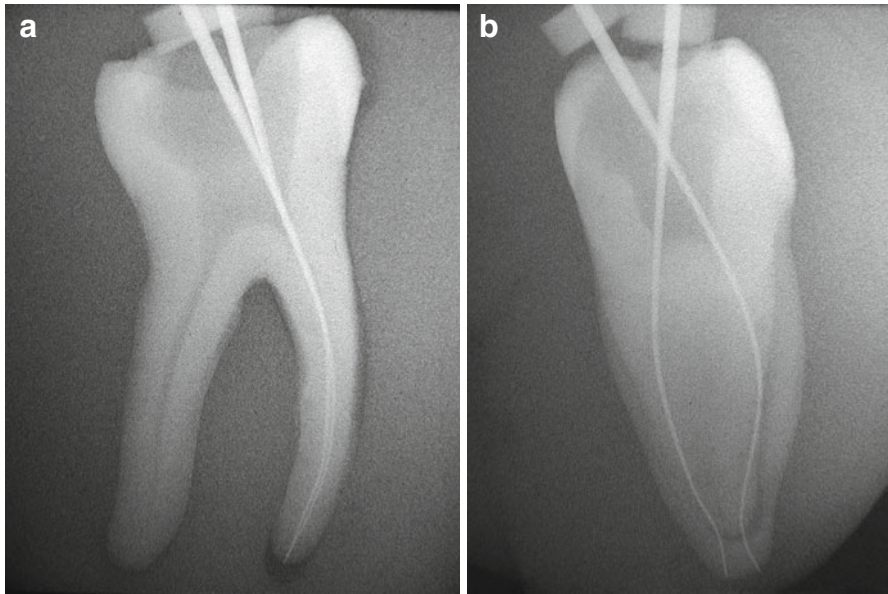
(a) Radiograph in buccolingual projection. The file inserted into the MB and ML canals points up the buccal curvature of the canals, the only curvatures visible through radiography on the patient. (b) Radiograph in proximal projection. The file inserted into the MB and ML canals points toward the proximal curvatures of the canals, which are impossible to visualize through radiography on the patient
